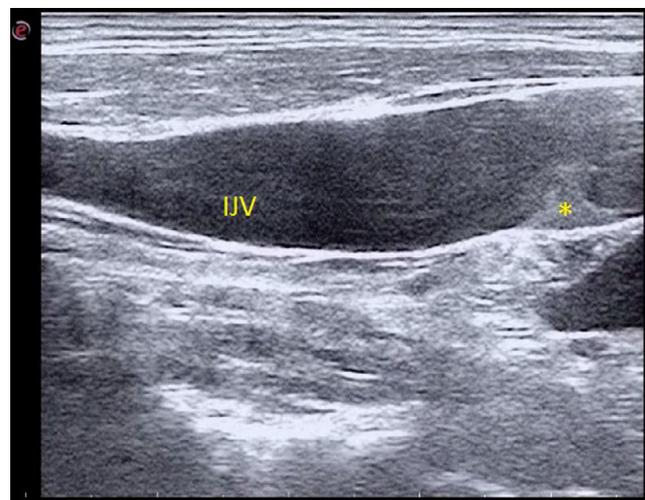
Ultrasound in a longitudinal view showing a valve with thrombus (*) in the right internal jugular vein. IJV, internal jugular vein.
